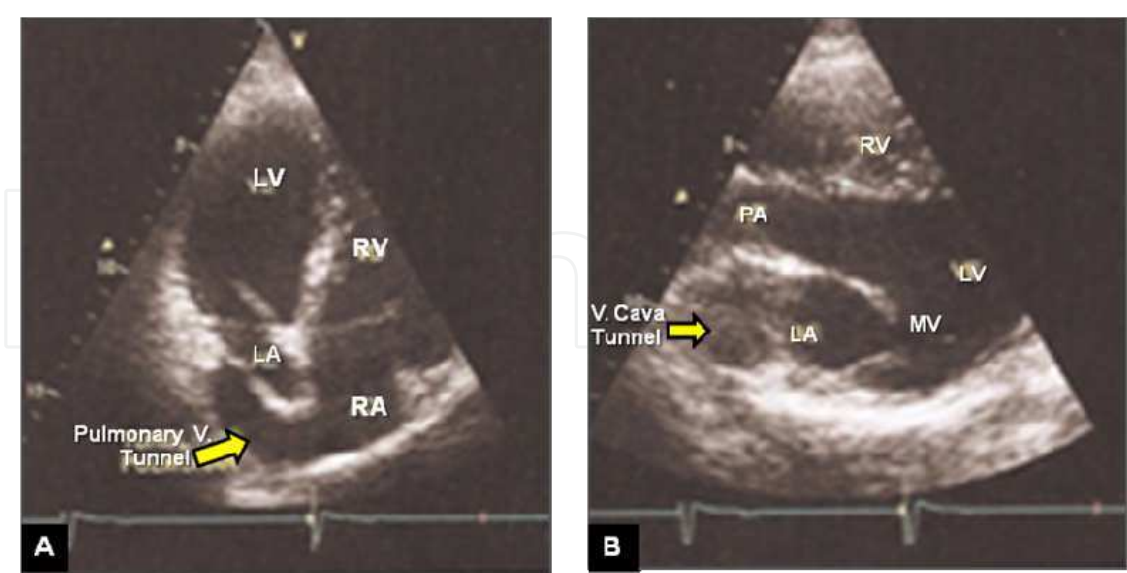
Post-operative Doppler-echocardiogram study. Patient: male, 16 years-old, in late follow-up of Senning operation. A- Pulmonary vein tunnel draining into right atrium (arrow). B- Vena cava tunnel draining into the left atrium. RA: right atrium; LA: left atrium; RV: right ventricle; LV: left ventricle; V: vena .
